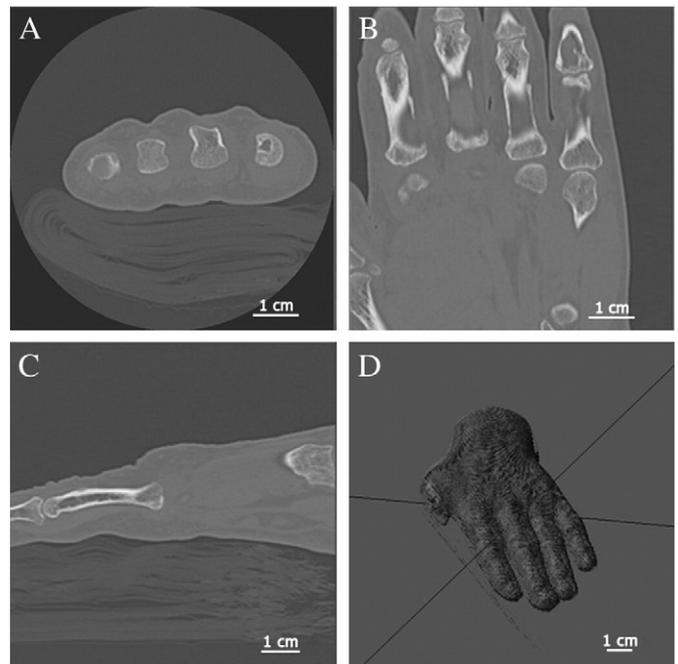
Multiplanar 2D Images acquired from a CT scan and 3D hand volume. Z-axis (A), Y-axis (B), X-axis (C), images acquired by CT. Patient's hand generated 3D volume is presented in (D).
